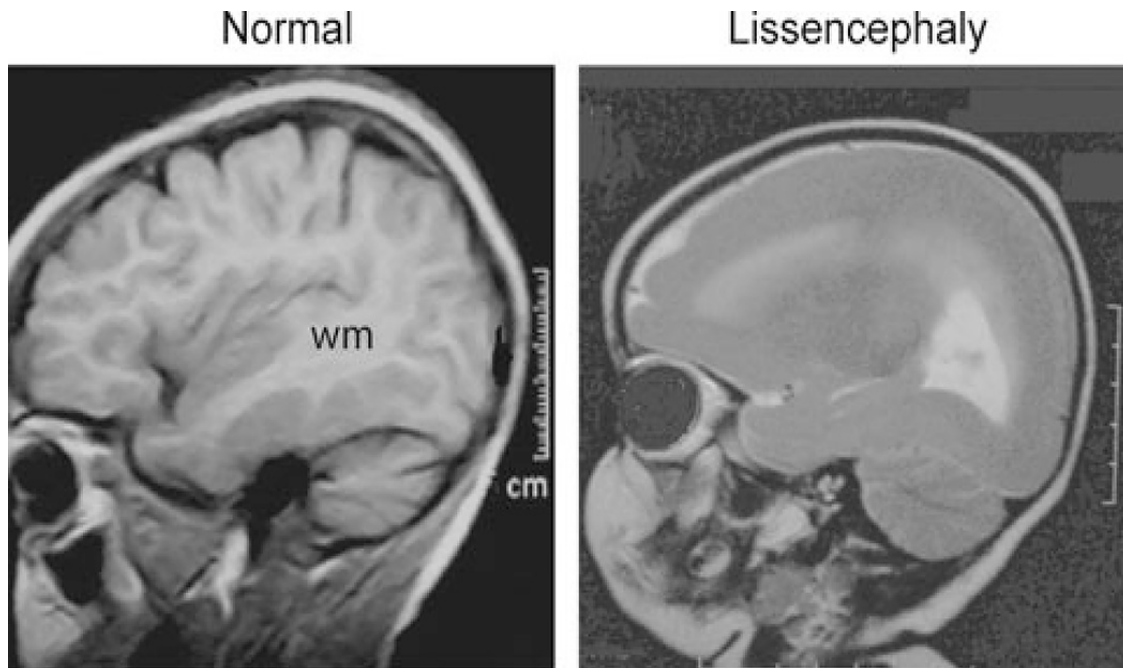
Figure above- MRI imaging comparing typically developing brain with complete lissencephaly
